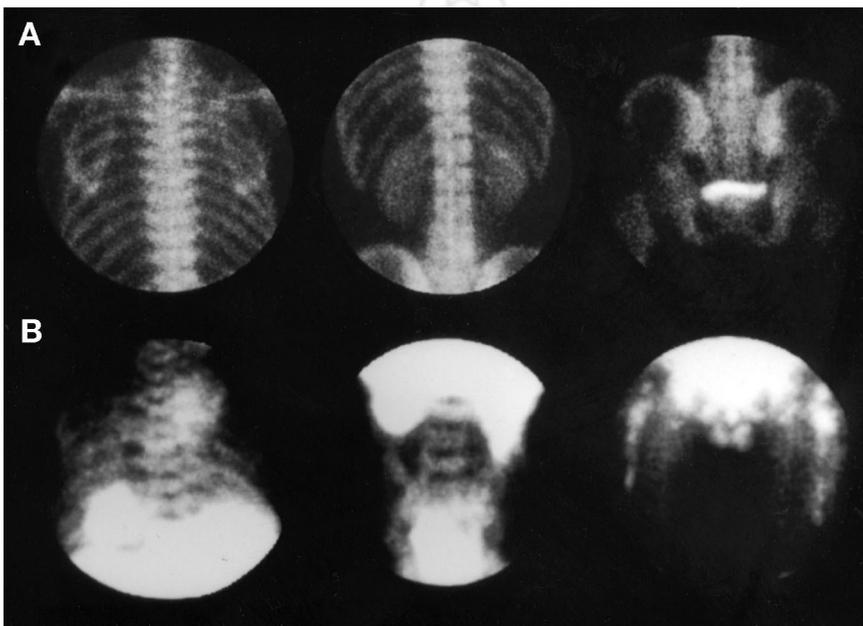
Patient with lung cancer. (A) ^{99m}Tc -HMDP scans show no definite bone metastases, although anterior pelvis image could not be obtained. (B) ^{99m}Tc -MIBI scans show increased uptake in multiple regions of ribs, in thoracic and lumbar spine, and in right lung tumor and also show irregular-shaped uptake in bilateral proximal femur in anterior pelvis image. MRI showed multiple metastases in thoracic spine, and bone marrow cytology from puncture sites on sternum showed many lung cancer cells.
